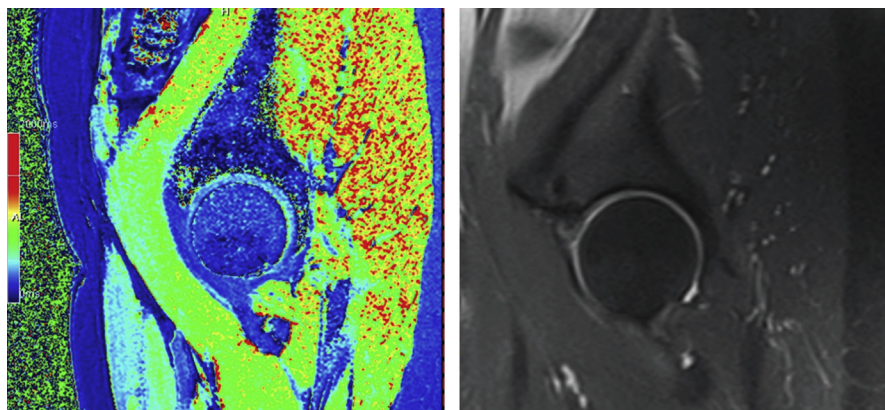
dGEMRIC (*left*) and sagittal T2 weighted MRI images (*right*) demonstrating well-preserved cartilage in a 36-year-old patient being considered for revision hip arthroscopy.
